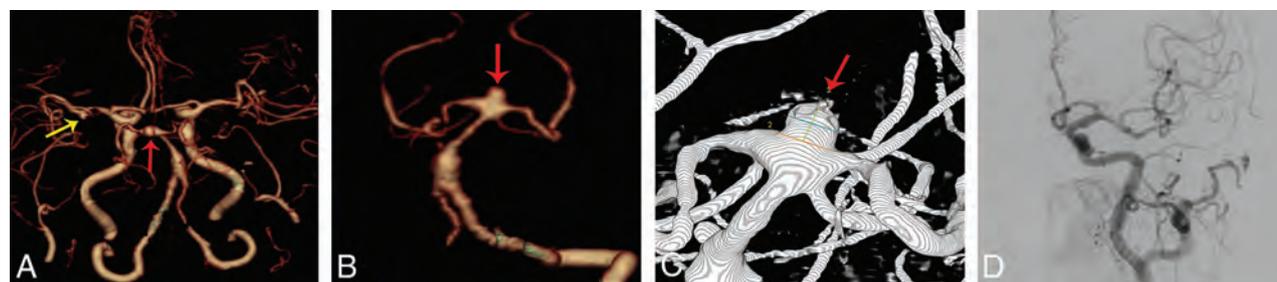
A 120-kVp cerebral CTA with 60 mL of contrast agent in a 70-year-old woman. *A* and *B*, Volume-rendered digital subtraction CTA images show a true-positive aneurysm in the top of basilar artery (red arrow), which was confirmed by 3D-DSA (*C*) and a false-positive aneurysm in the left middle cerebral artery (yellow arrow), which was not evident in 2D-DSA.
